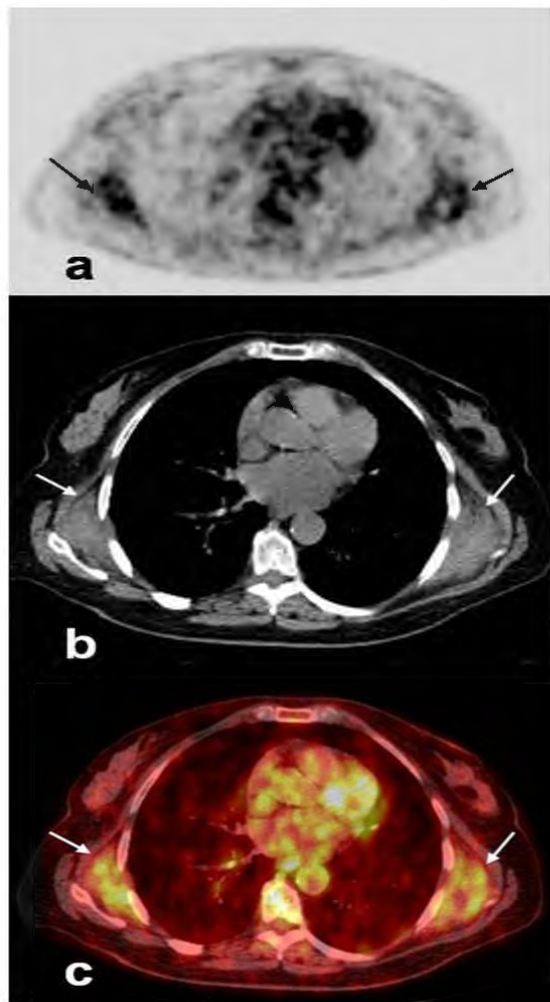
78 year old female with elastofibroma dorsi. In view of PET (a), CT (b) and fusion (c) images obtained in the axialplane, orientation to localization of the lesion is also easier, FDG uptake is observed as deep-located in serratus anterior muscle in infrascapular localization.
